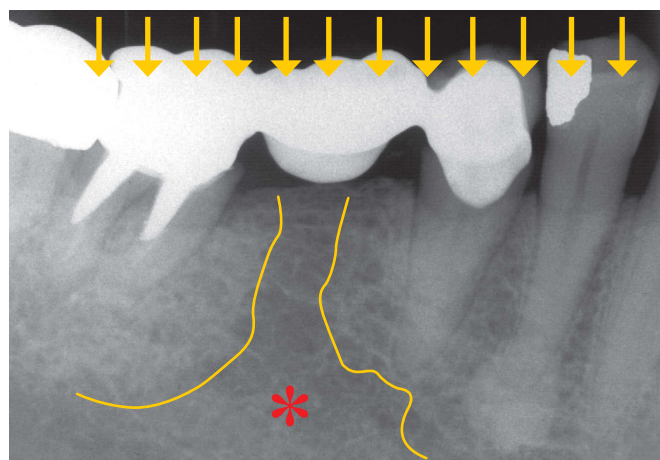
The bone area which receives masticatory forces present denser trabecular bone, with thicker trabeculae and smaller marrow spaces — a process known as sclerosis or bone condensation. In some places, the spaces are not even identified in radiographic images, such as in the first premolar periapical region. In the area outside the lines, bone sclerosis appears more than in the central region defined by the two lines and the asterisk, clearly by the lack of masticatory load in the site. Bone dynamism meets the functional demands.
